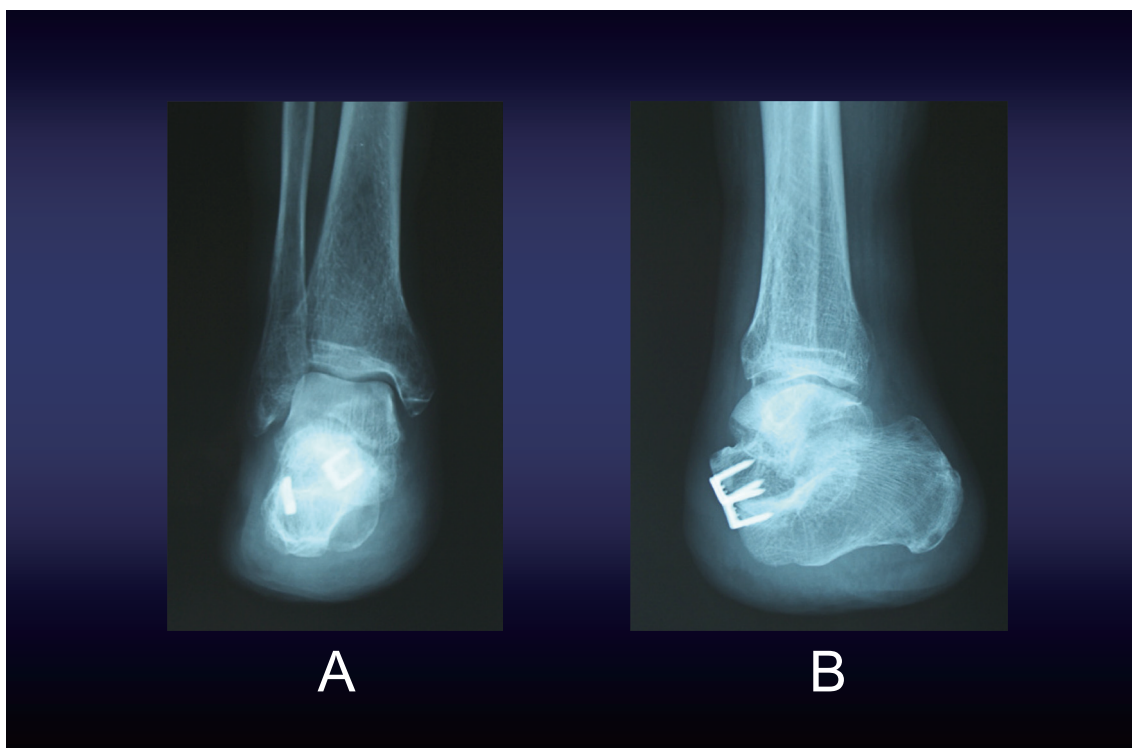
Postoperative radiograph. 2-A, anteroposterior view ; 2-B, lateral view. Varus and equinus deformity was not observed.
